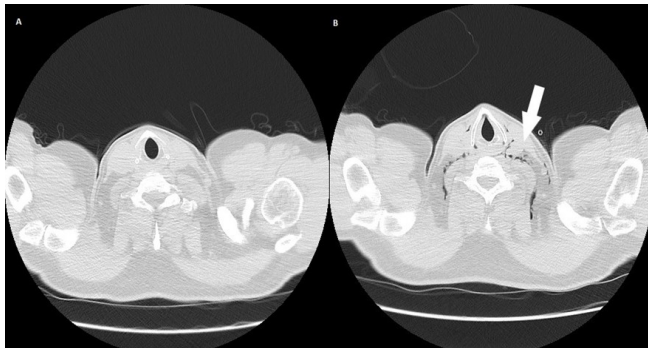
(A) ground-glass opacity with 50% distribution bilaterally (CT on admission); (B) ground-glass opacity with 60%–70%, distribution bilaterally, pneumomediastinum (arrows).
